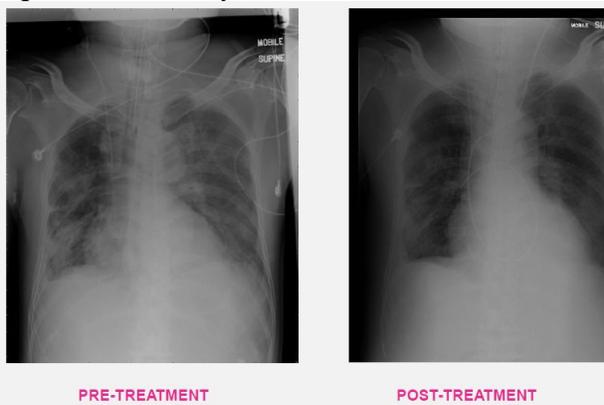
Chest x-ray of ARDS patient after single D2000 treatment
